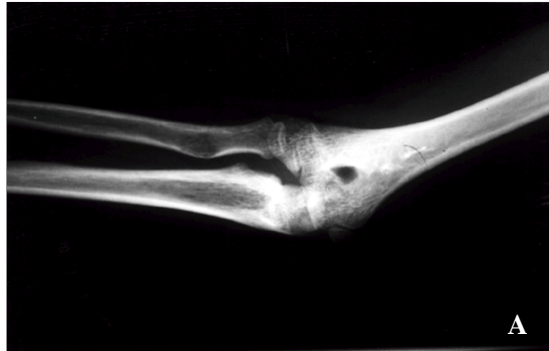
10-year-old boy who had been treated with closed reduction and cast immobilization after a trauma 3 years and 6 months ago. (A,B) Preoperative radiographs show anterior radial head dislocation and anterior ulnar bow sign. (C,D) Immediate postoperative radiographs. (E) Final follow-up radiograph.
